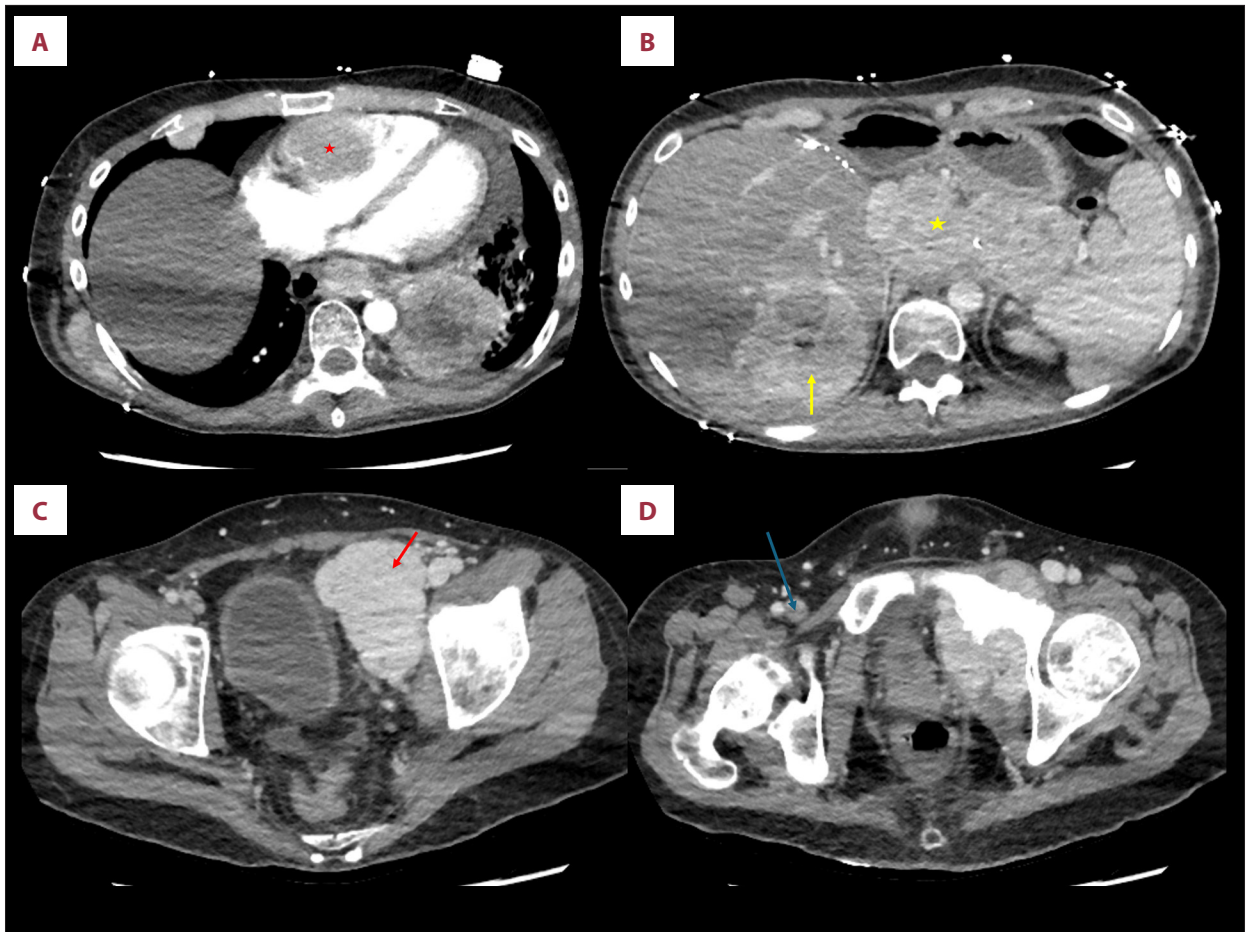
Contrast-enhanced computed tomography (CT) demonstrates widespread metastatic disease and thrombotic complications. Axial CT images show (A) a large intracardiac mass within the right ventricle (red star); (B) a 7.6 × 7.9 cm hepatic mass (yellow arrow) with additional intraperitoneal tumor deposits (yellow star); (C) a pelvic mass (red arrow); and (D) deep vein thrombosis in the right common femoral vein (blue arrow).
